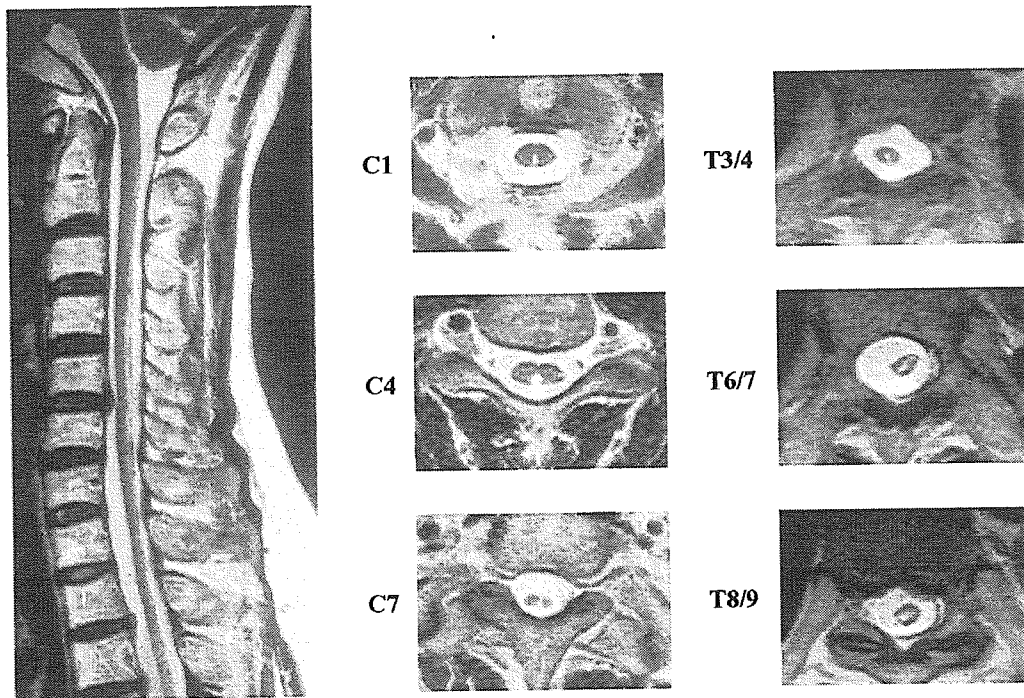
Representative longitudinally extensive spinal cord MRI lesions on T2-weighted images from a 52-year-old patient with OS-multiple sclerosis at relapse.
